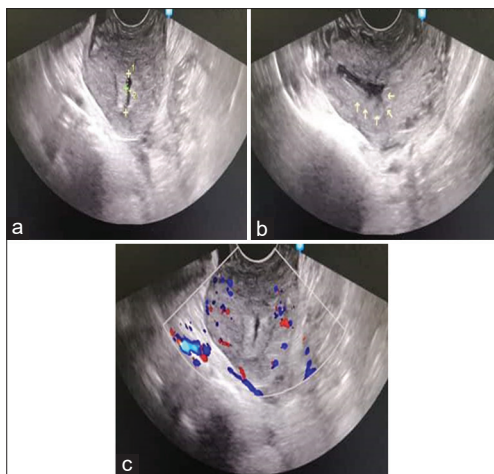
Transvaginal sonogram: (a) Normal sized uterus with an irregularly thickened hyperechoic endometrium; (b) anterior hyperechoic masses suggestive of polyps (arrows); (c) color mapping of the uterus and endometrium did not reveal any abnormal flow
